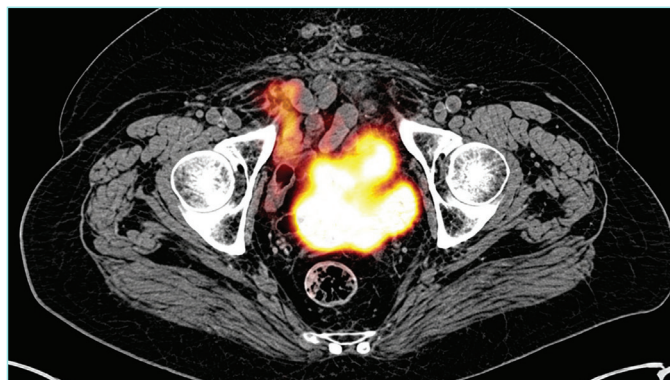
Bladder tumor image on PET/CT.
